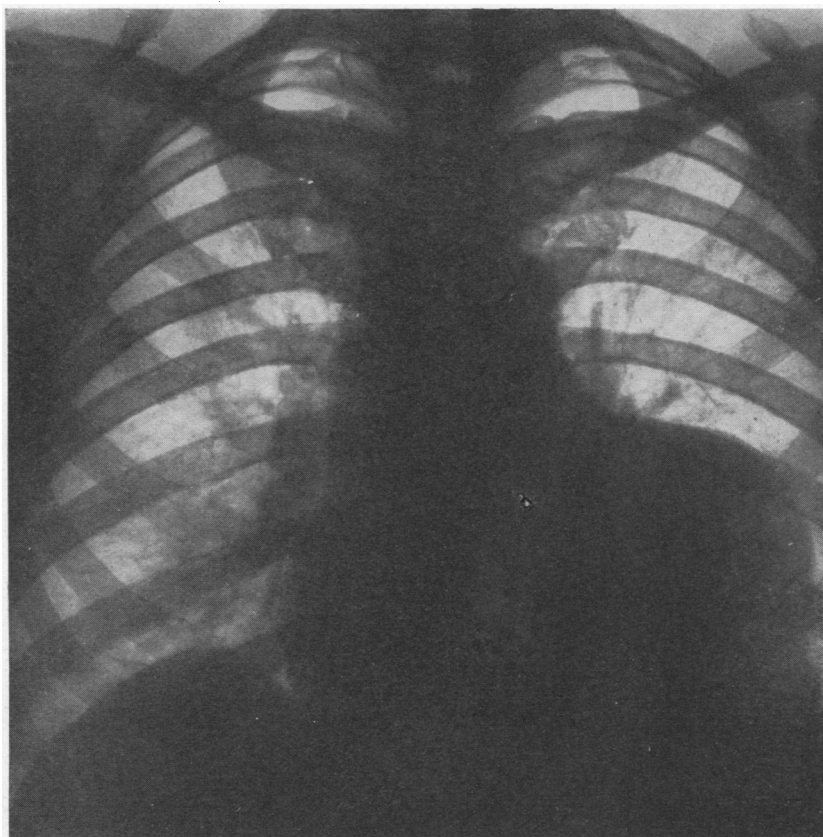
Postero-anterior radiograph showing outline of shadow continuous with cardiac border, and slight accentuation of vascular markings of the right lung.
